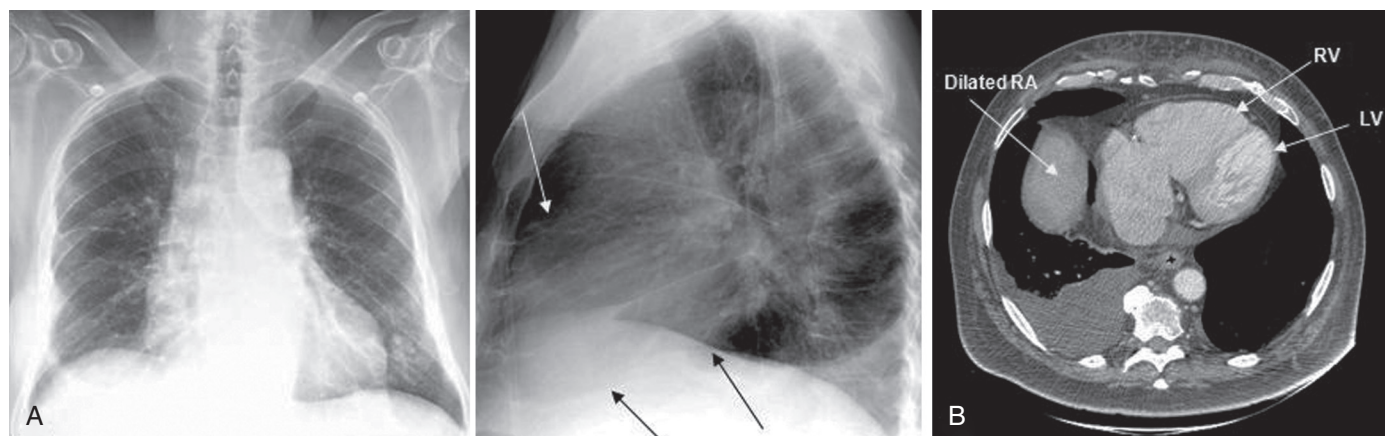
A, Radiographs of an older man with biventricular hypertrophy (note the boot-shaped heart on the PA view, arrows on the lateral view), marked pulmonary vascular redistribution (note the haziness and loss of definition of margins of the pulmonary vessels throughout), and right pleural effusion. B, CT scan confirming biventricular hypertrophy, with the right ventricle (RV) larger than the left ventricle (LV), enlargement of the right atrium (RA), and right pleural effusion.
